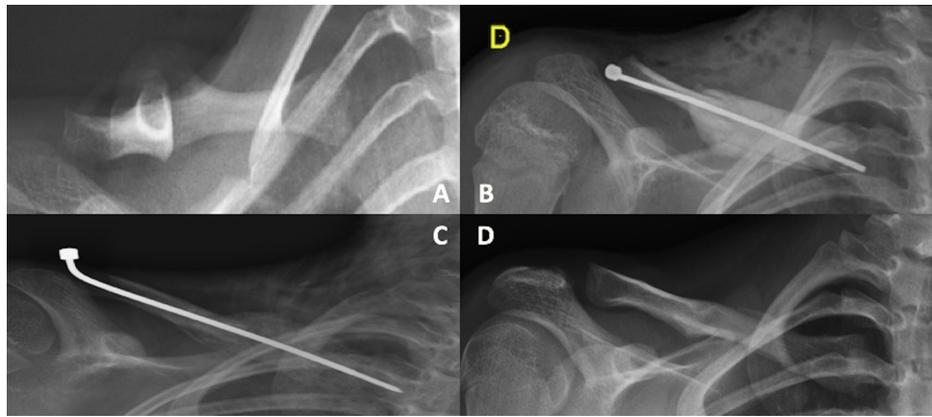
Patient #1, clavicular reconstruction for congenital pseudarthrosis of the right clavicle. A. Pre-operative radiograph. B. Radiograph taken immediately after the first stage of the induced membrane procedure. C. Radiograph taken immediately after the second stage of the induced membrane procedure. D. Radiograph taken at last follow-up after 8.4 years, showing bone healing.
